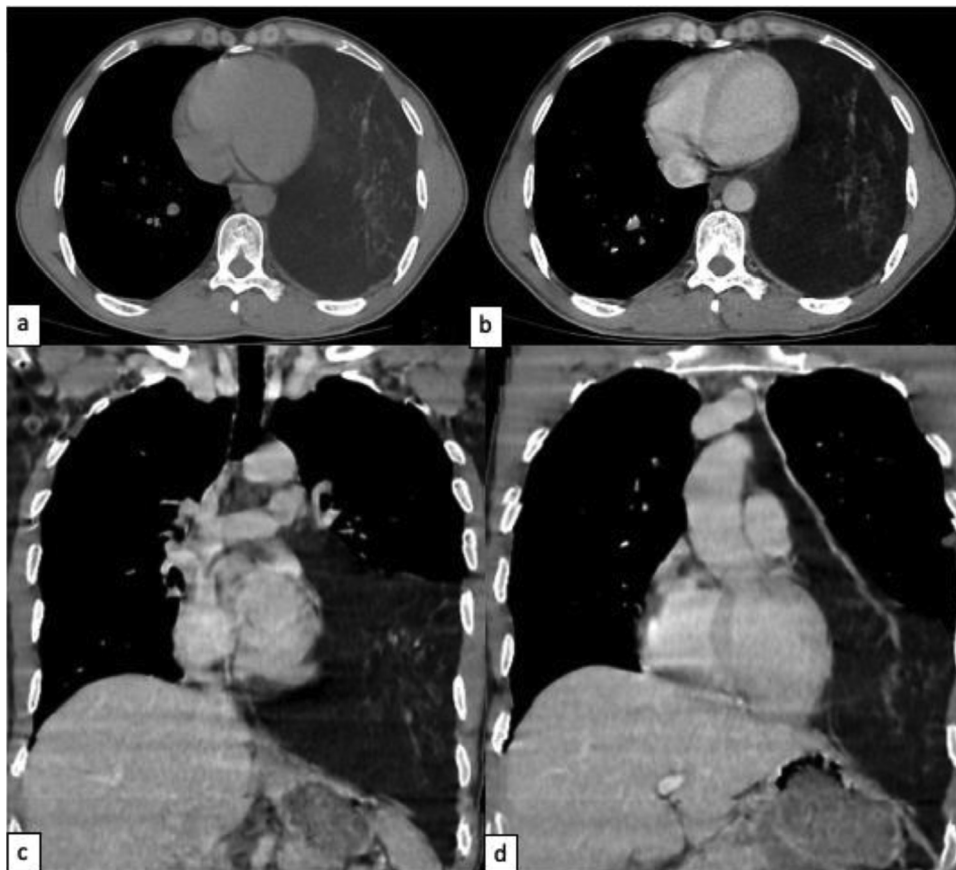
Unenhanced (A) and contrast-enhanced chest CT scan on the axial (B) and coronal (D,C) sections: revealed a large well-defined heterogeneous mass with predominance of fat attenuation values mingled with focal areas of soft tissue density, which extended from the anterior mediastinum to the left diaphragm, displacing the lung superiorly.
